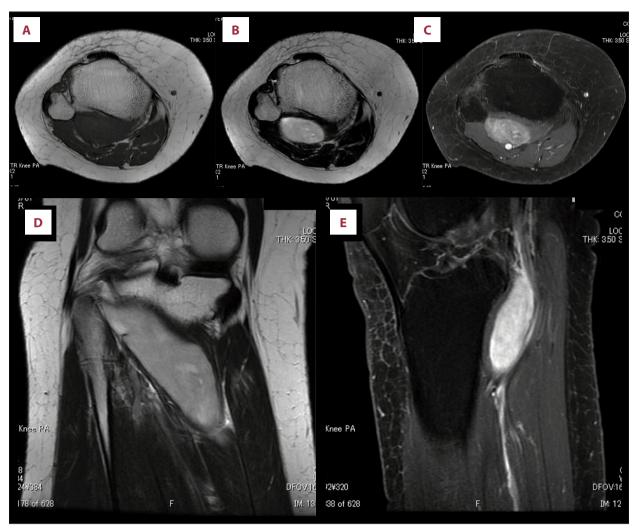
Magnetic resonance imaging (MRI) showed a tumor with clear margins in the popliteus muscle. (A, B) T1- and T2-weighted axial images, respectively. (C) Gadolinium-enhanced fat-suppressed T1-weighted axial image. (D) T2-weighted coronal image. (E) T2-weighted sagittal image with fat suppression.
